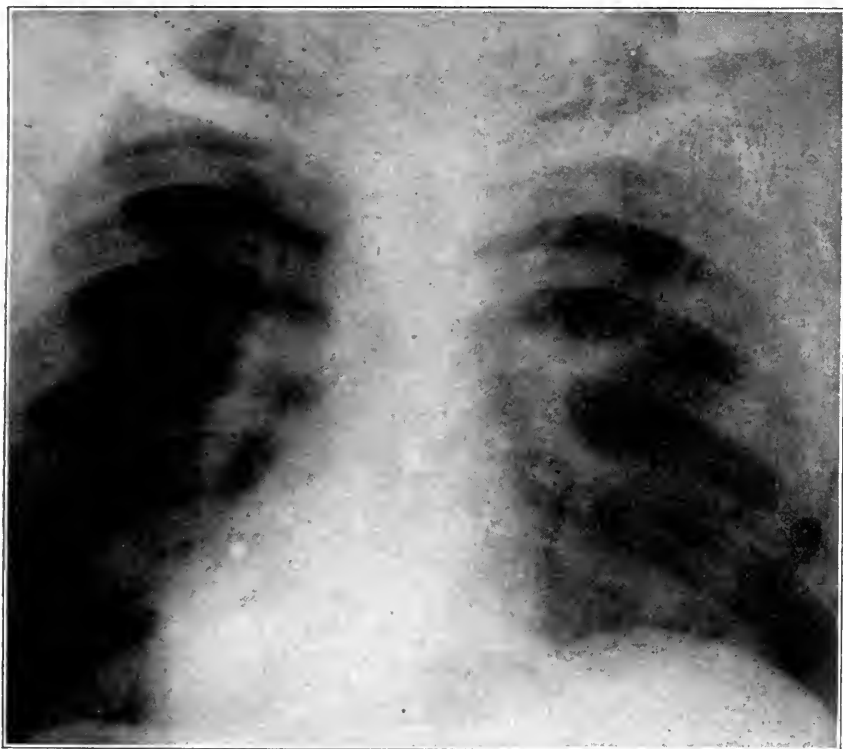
Case 853. Roentgenogram of the lungs in a fairly early case with typical bronchial annular shadow extending from the first to the third rib on the right side. This shadow may be seen best by means of stereoscopy.
